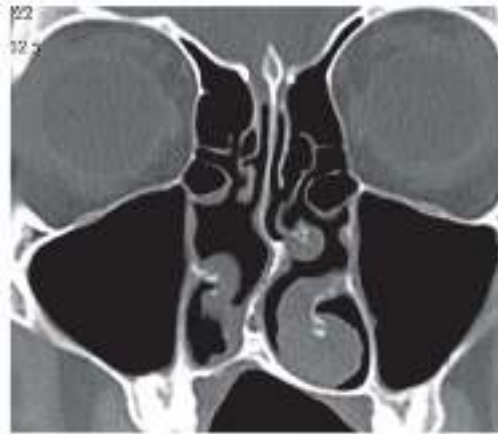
CT PNS in Coronal plane showing Inferior turbinate hypertrophy.³⁴
